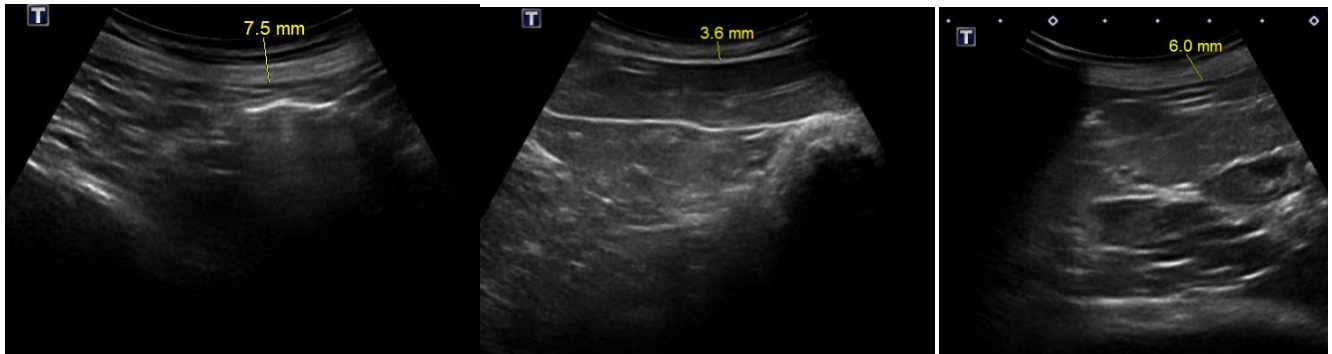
Ultrasound images of the abdominal protrusion using a 3.5MHz convex probe, showing gradual decrease in body wall thickness. Left image is caudal mass, middle image is central mass and right image is cranial mass.
